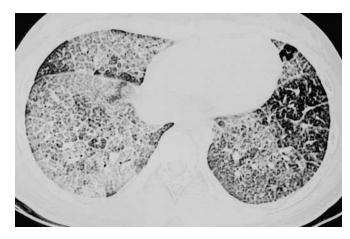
Thin-section, high-resolution computed tomography scan of the thorax showing features typical of acquired PAP. Extensive opacity involves most of the lungs. The areas of ground-glass opacity demonstrate thickening of the interlobular septa leading to the characteristic "crazy paving" appearance typical of PAP.
